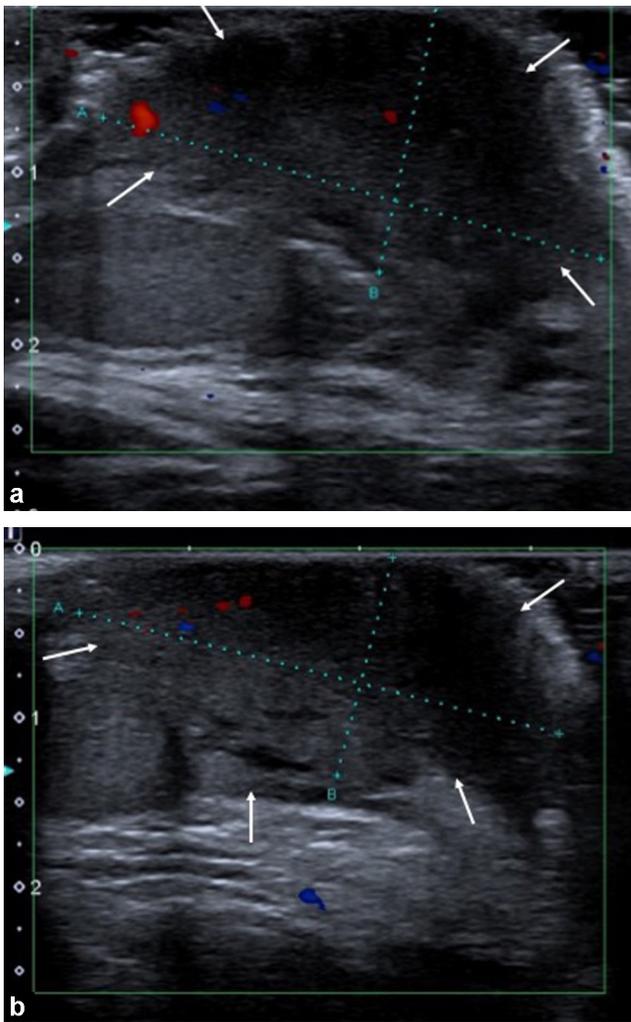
4-year-old boy with severe hemophilia A presenting with acute scrotal pain and swelling of the scrotum with no reported trauma. Color Doppler ultrasound of right testis (A) and left testis (B) reveals bilateral intrascrotal hematomas (arrows) surrounding the testes, ruling out testicular torsion. Symptoms resolved within 24 hours after clotting factor replacement therapy, and surgery was avoided.
